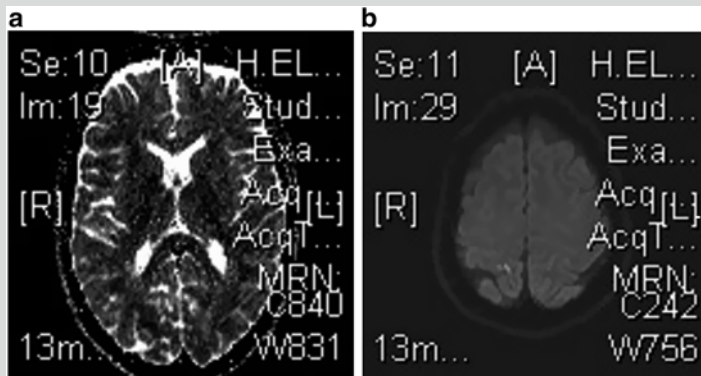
Diffusion weighted image (DWI) (b) and apparent diffusion coefficient (ADC) (a) images showing a small right parietal infarct
